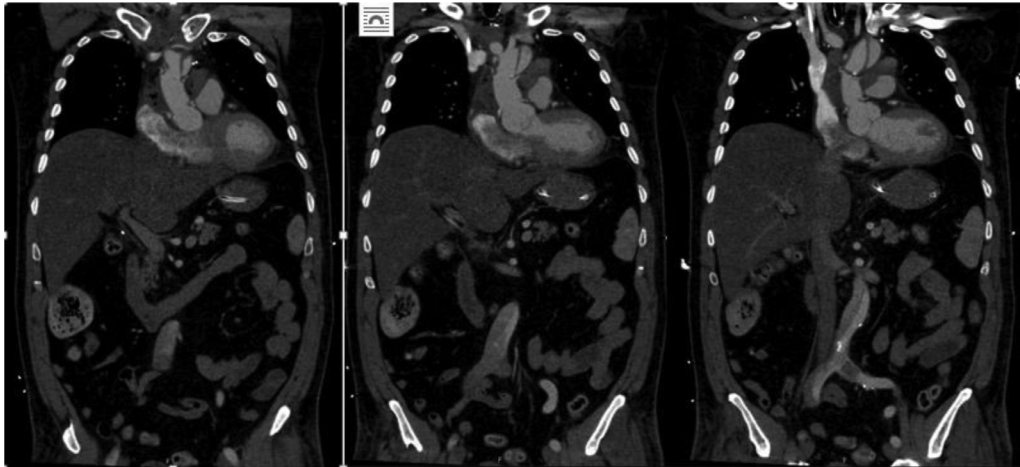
CTA suggesting type A dissection extending to involve both iliac arteries.
